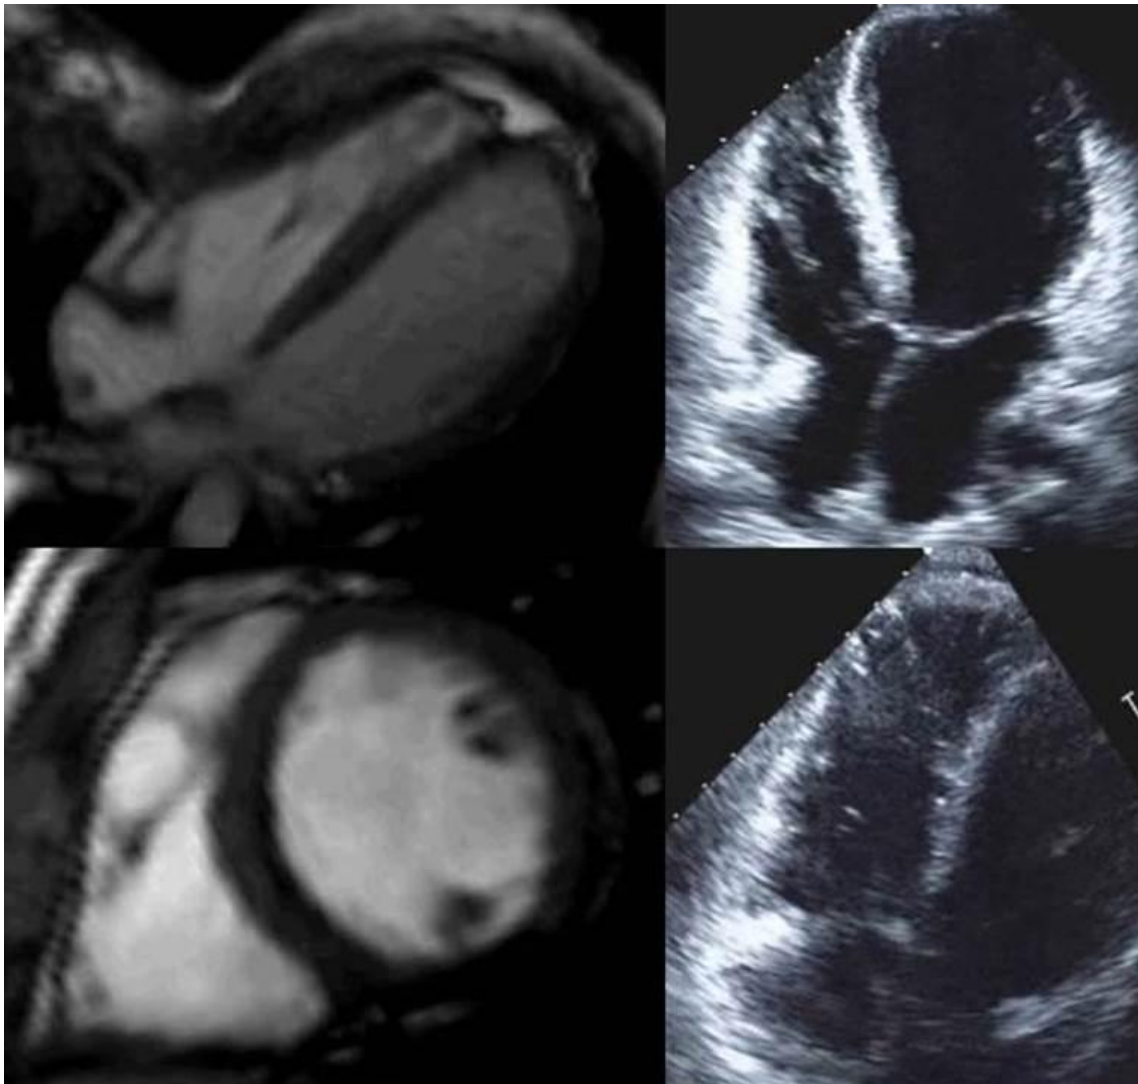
Proband's echocardiogram and CMR revealed normal biventricular volumes, severe biventricular dysfunction and absence of LGE.
